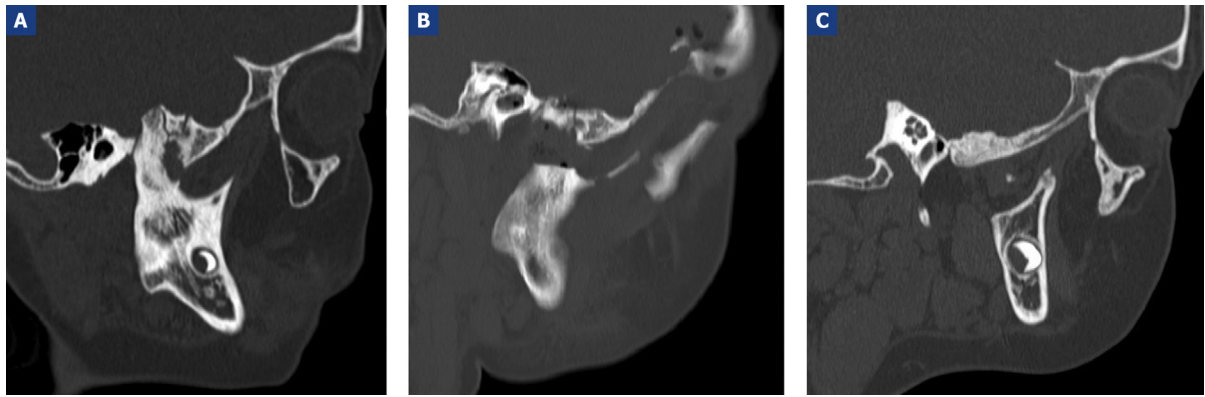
CT scan, sagittal view; A: before surgery CT scan, showing the irregular shape of the right condyle dislocated in the middle cranial fossa; B: after surgery, showing the extent of the right condyle removed; C: one year after surgery, showing completely remodeled floor of the middle cranial fossa without continuity between the two regions.
